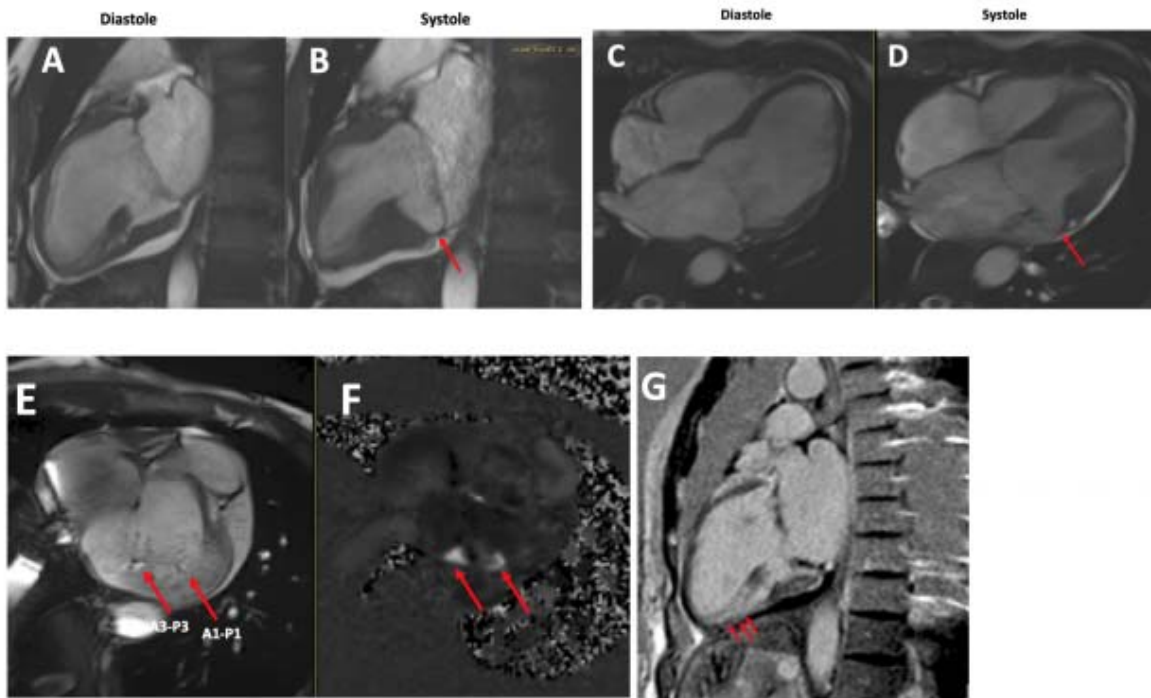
A-D) Cardiac magnetic resonance imaging shows the MAD in the four chamber image (labeled) E) Cine image showing MR jets from A1-P1 and A3-P3 scallops, F) Flow mapping showing MR jets from A1-P1 and A3-P3 scallops, G) LGE images showing the mild fibrosis at the LV inferolateral wall.
